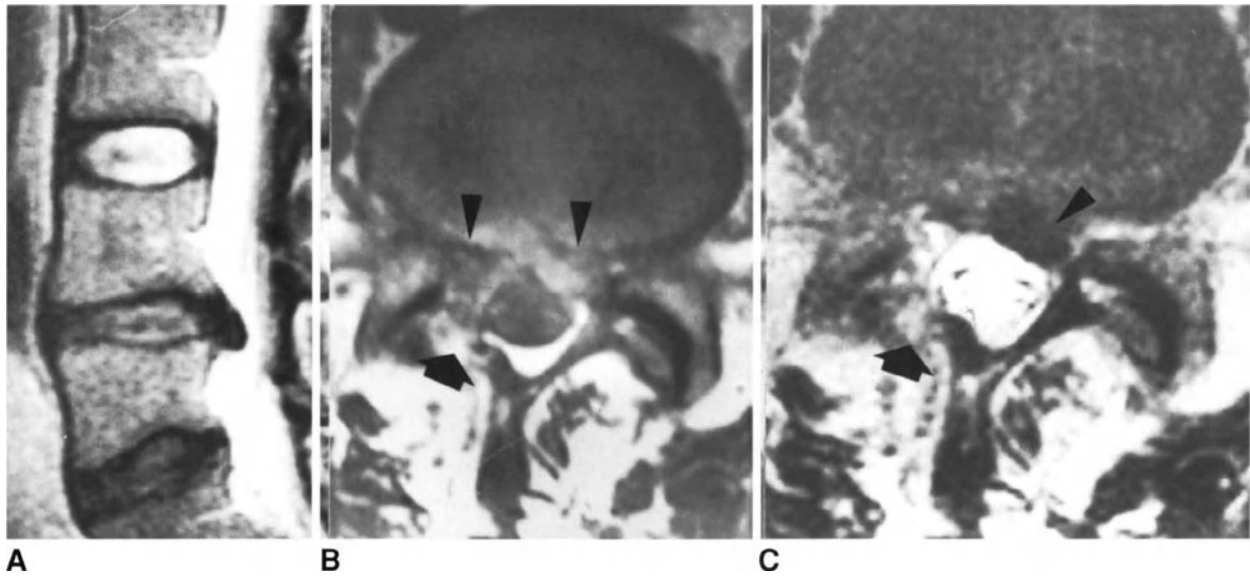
Contralateral herniation at the operated level. MRI sequences obtained 4 years after primary discectomy. (A) Spin-echo T2-weighted sagittal image showing an extruded herniation at L4-L5 level. (B) Spin-echo T1-weighted axial image, which reveals the previous laminotomy on the right side (arrow) and tissue occupying the radicular canal on both sides (arrowheads). (C) Spin-echo T2-weighted axial image showing, in the left radicular canal, abnormal tissue (arrowhead), with a signal intensity similar to that of the disc. The arrow indicates the previous laminotomy.
